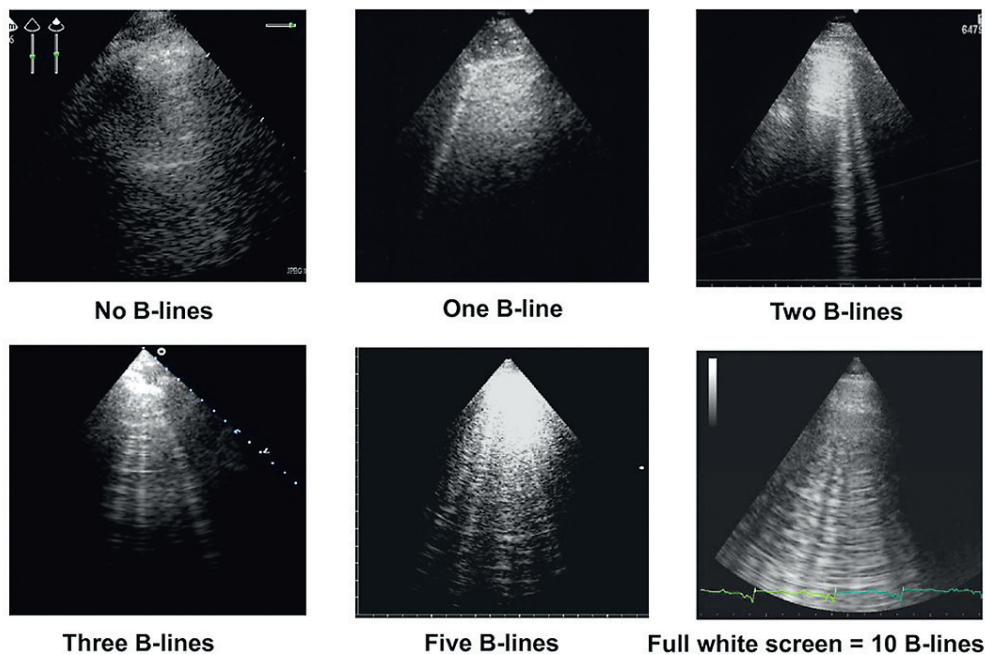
Single and multiple presence of B-lines in the ultrasound picture of the lung [14]
